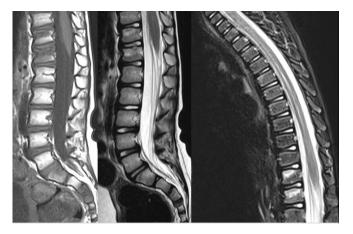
Spine MRI showing normal positioned conus and syringomyelia. Signal changes in D11-D12 vertebral bodies
